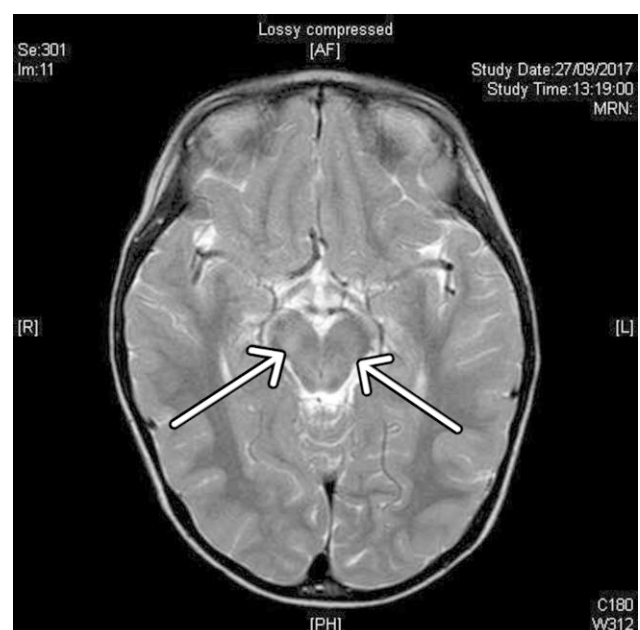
MRI brain showing T2W hyperintense signals over bilateral posterior pons (arrows).
